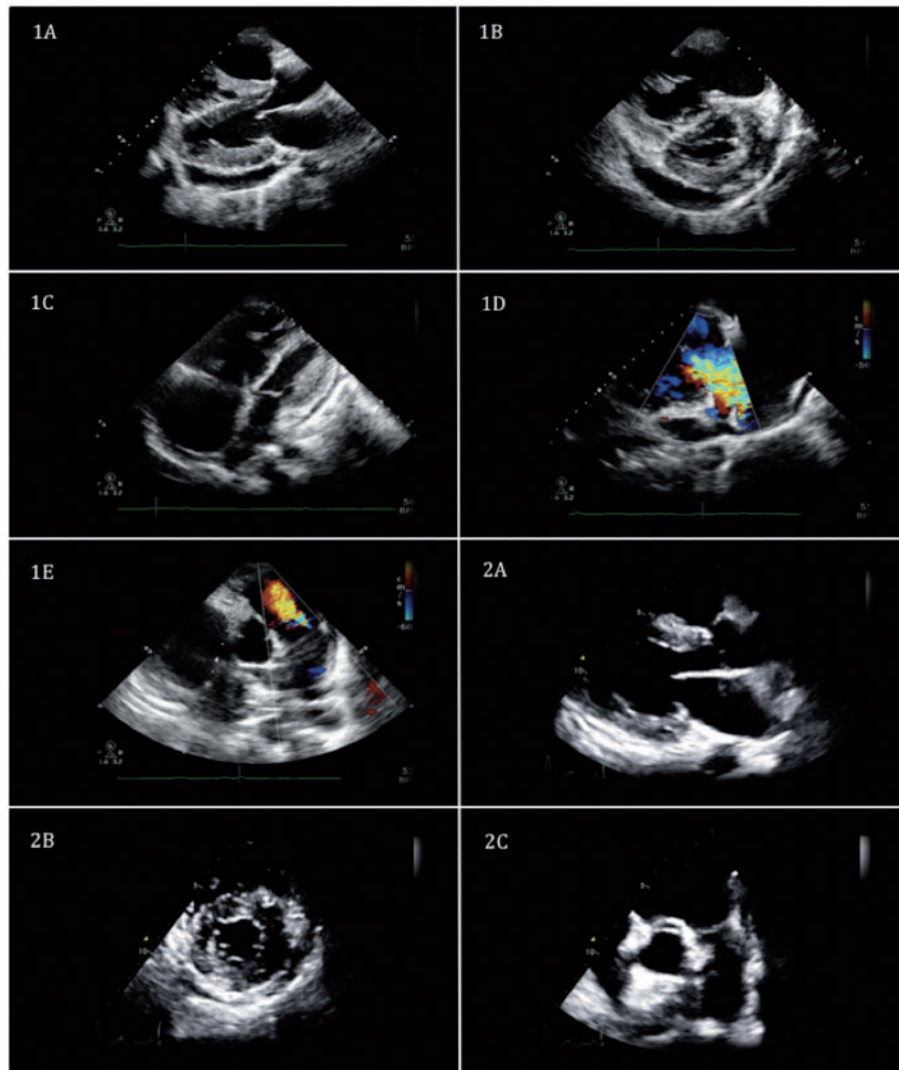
1. TTE 2015: (1A) parasternal long axis showing moderate pericardial effusion, (1B) parasternal short axis showing D-shaped septum in diastole, (1C) apical view showing massive RV, (1D) Tricuspid regurgitation, (1E) Pulmonary regurgitation 2. TTE 2017: (2A) parasternal long axis normal, (2B) normal in short axis, (2C) apical view normal.
